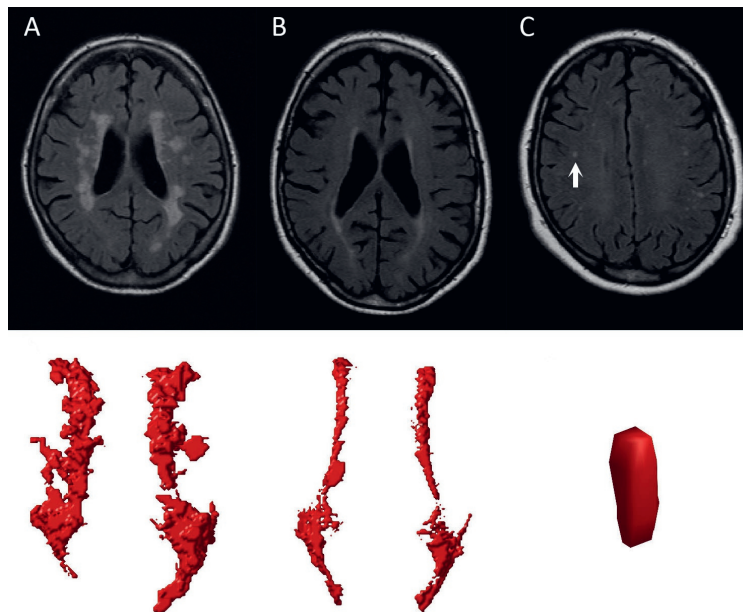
Examples of confluent (A), periventricular (B) and deep (C) WMH on FLAIR images with the corresponding visualizations in our algorithm shown below. The deep WMH lesion (arrow) is reconstructed in the coronal view, while the periventricular and confluent WMH are viewed from a transverse perspective. Note that the coronal reconstruction of the deep WMH lesion (C) may be influenced by the slice thickness and the lesion may be more punctiform. The confluent WMH lesion in A showed a volume of 11.57 mL with an accompanying deep WMH volume of 0.25 mL. The periventricular WMH lesion in B showed a volume of 4.98 mL without any accompanying deep WMH lesions. The deep WMH lesion in C showed a volume of 0.02 mL with an accompanying periventricular and deep WMH volume of 2.12 mL and 0.49 mL, respectively.
